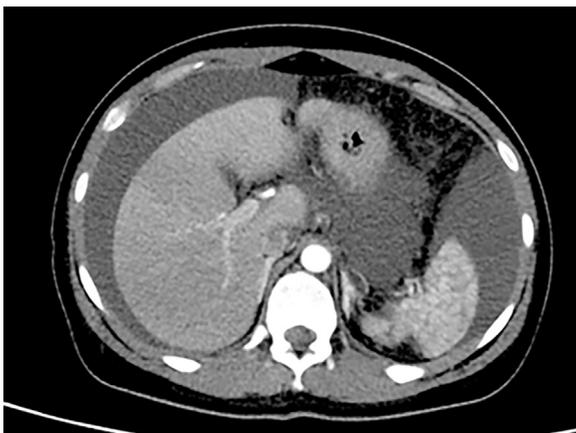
Axial computed tomography scan shows a large amount of free fluid surrounding the liver and the spleen.
